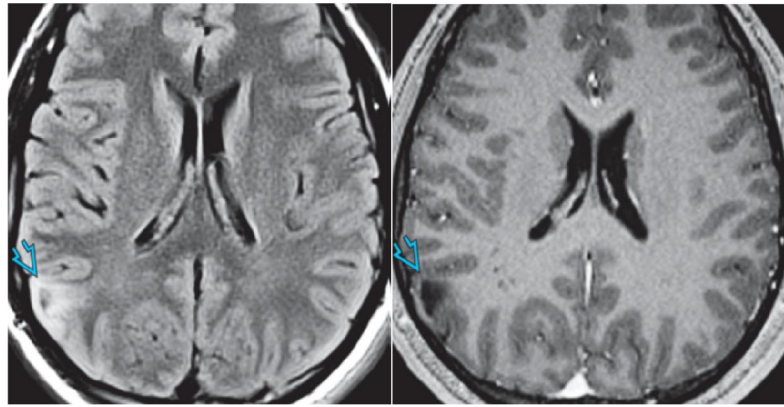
Axial FLAIR MR shows a wedge shaped hyperintense cortical and subcortical mass in the right parietal lobe, lack of surrounding edema. Axial T1 C+ MR in the same patient shows no enhancement within the mass, a typical finding in angiocentric glioma.
